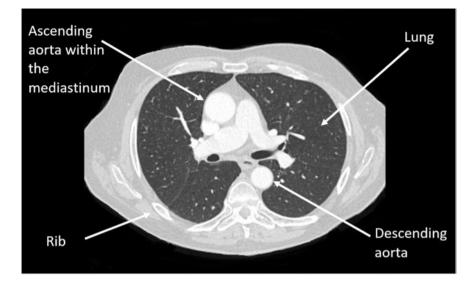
Axial contrast-enhanced CT of the chest presented in lung windows
